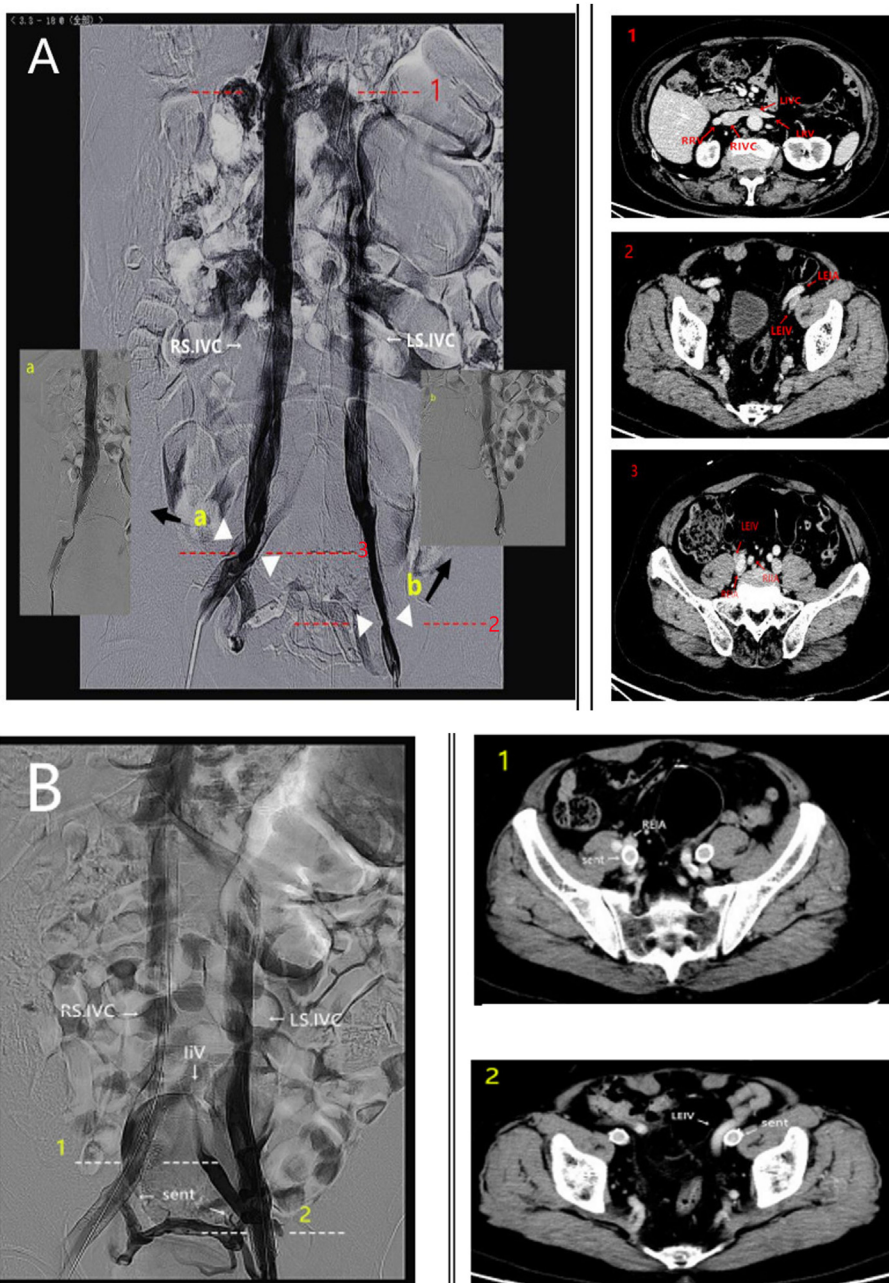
A: Contrast-enhanced CT and Intraoperative venography. Of note, the right IVC is entrapped with the right CIV. The left IVC is merged between the SMA and aorta (dotted line 1). LEIV stenosis is caused by compression from the left external iliac artery and surrounding iliopsoas (dotted line 2; arrowhead b). The right CIV is approximately 50% compressed between the right common iliac artery and the fifth lumbar vertebral body (dotted line . 3; arrowhead a). B: Successful deployment of the stent in the affected segment with a resolution of stenosis. CIV, common iliac vein; IVC, inferior vena cava; Ls, left side; Rs, right side; SMA, superior mesenteric artery. LEIV, left external iliac vein.
